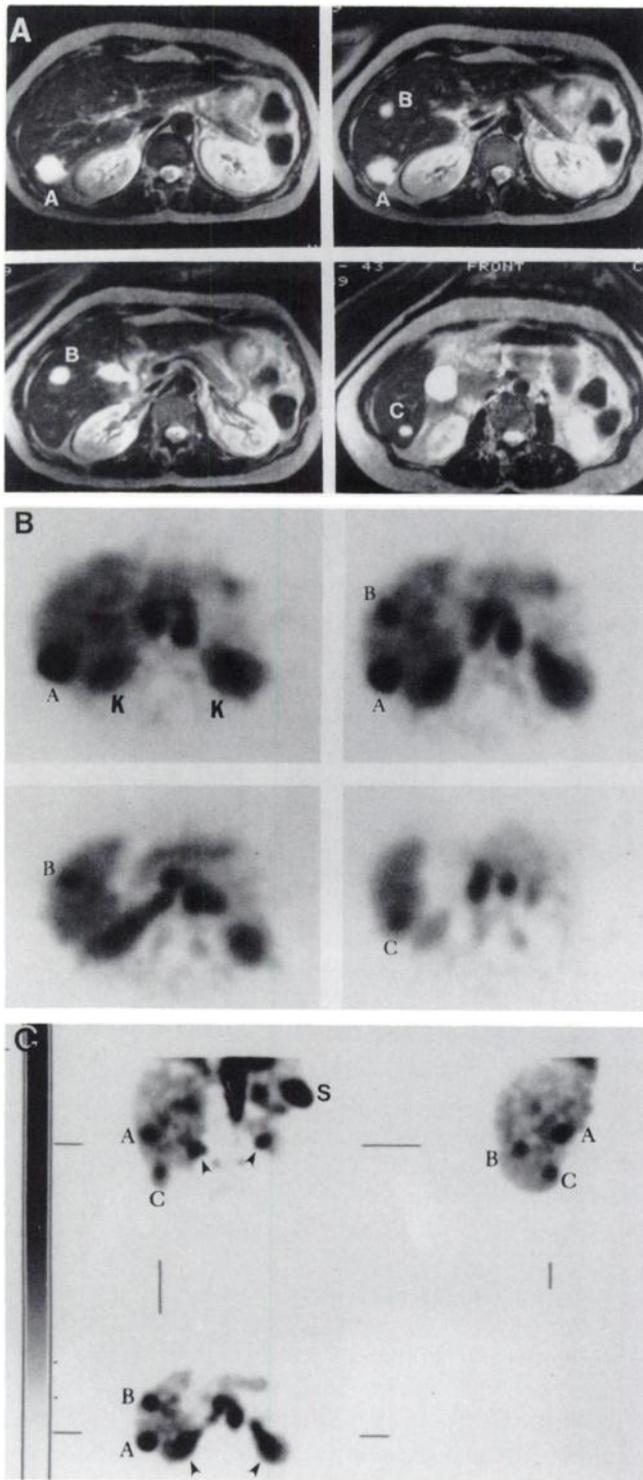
(A) T2-weighted MR study with four selected slices (from top left to bottom right) showing three hemangiomas measuring 2.5 (A), 1.8 (B), and 1.0 cm (C) in size. The MR and Tc-RBC studies were ordered as a result of abnormal ultrasonography demonstrating the two larger lesions. (B) Three-headed SPECT with transaxial slices comparable to the selected MR cuts in A. All three images (A, B, C) are hemangioma-positive. The kidneys (K) are noted. (C) Three-view computer display with triple-headed SPECT (same patient in B). Two lesions are clearly seen in the coronal and transaxial views, and all three hemangiomas are seen in the sagittal slice. The
